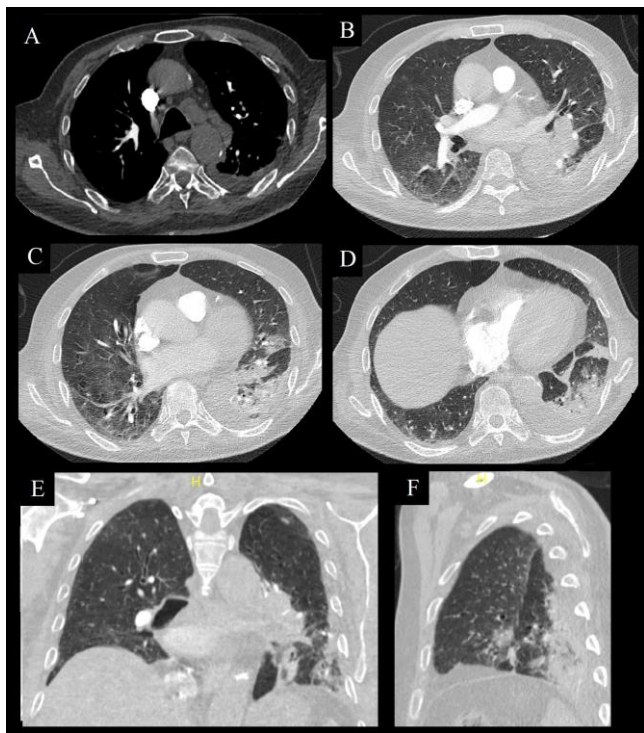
CT pulmonary angiography mediastinal window reveals a fusiform left lower paratracheal lymph node and a subcarinal lymph node with a short diameter of over 1 cm (a). In the axial section parenchyma window, there is pneumonic infiltration in the upper lobe lingular segment of the left lung and in the lower lobe, where air bronchograms are also monitored. There is parapneumonic effusion in the left lung as well as band atelectasis in the lower lobe basal (b-d). In the coronal section parenchyma window, pneumonic infiltrations are seen in the left lung (e). In the sagittal parenchyma window, nodular infiltration of the upper lingular segment of the left lung and pneumonic consolidation with an airbronchogram in the basal and posterior segments of the lower lobe of the left lung are observed in the neighborhood of an oblique fissure (f)
